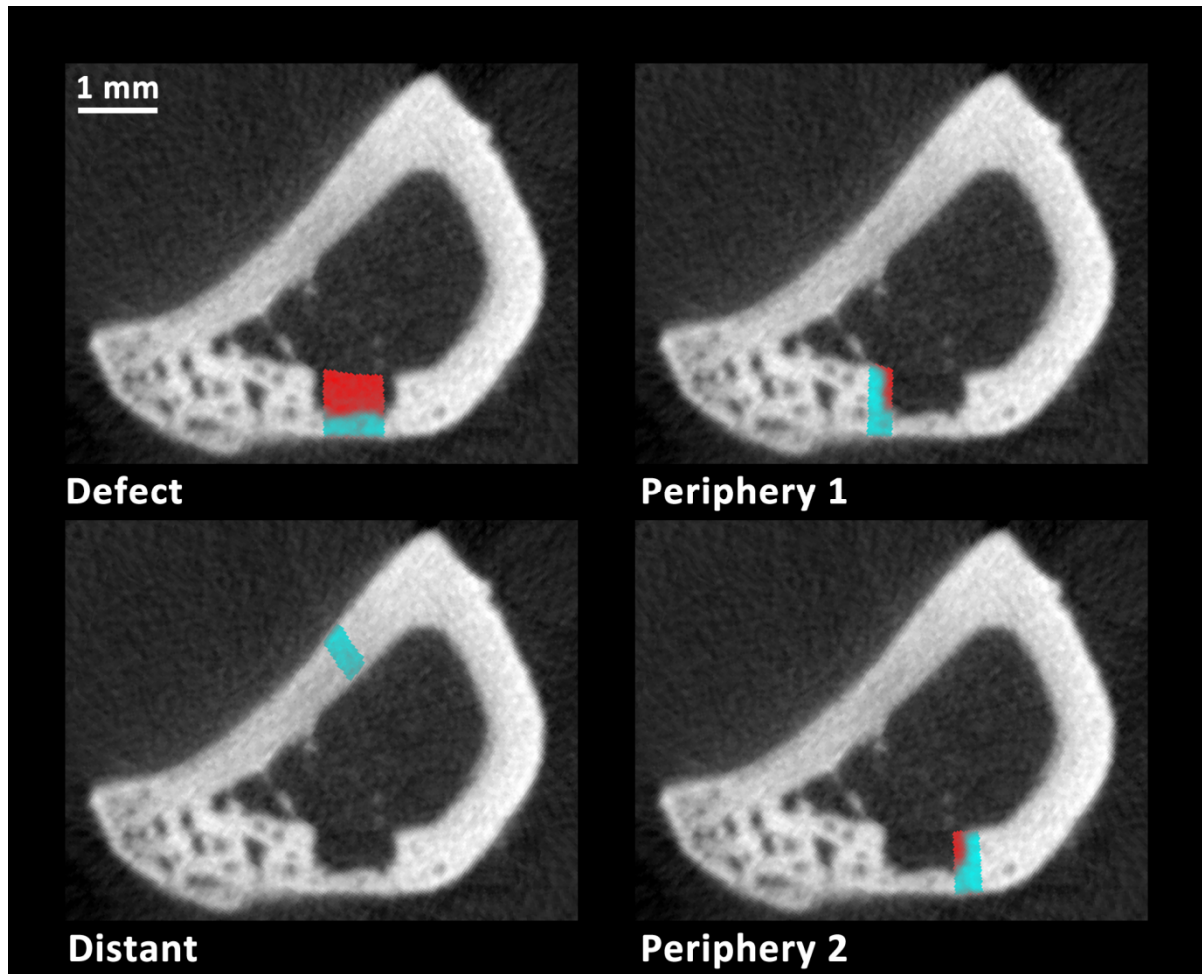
ROI Selections for μ CT Analysis. μ CT cross-section of the tibiae 3 weeks after ultrasonic osteotomy preparation demonstrating measured ROI selections for μ CT analysis with the CTAn software. The width of the Defect ROI was 0.50mm for R instrumentation and 0.60mm for both P1 and P2 instrumentation. The width of the Periphery 1, Periphery 2, and Distant ROIs was 0.25mm. Each peripheral ROI (left and right) was analyzed separately with the mean value of each sample used for analysis.
